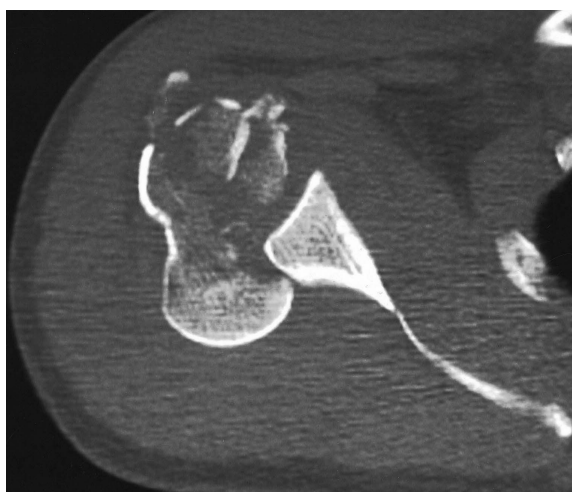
CT examination of the right shoulder shows posterior locked fracture-dislocation.
